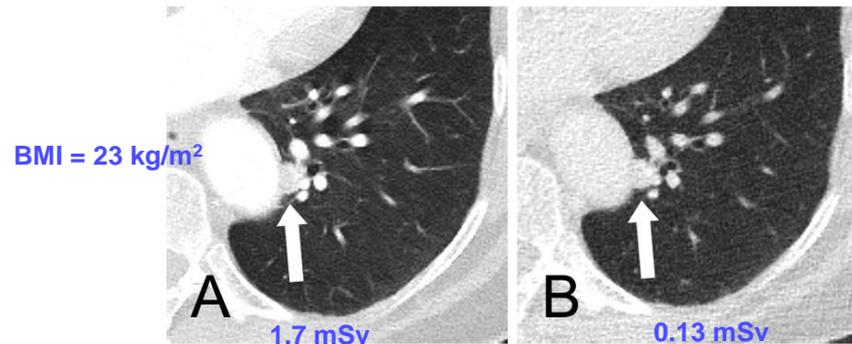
Representative transverse CT sections of the lung in a 73-year-old woman with a body mass index of 23.0 kg/m^2 scanned with standard dose (A) (effective dose 1.68 mSv) and ultralow dose (B) (effective dose 0.13 mSv). A 11 mm solid pulmonary nodule (arrow) in the left lower lobe adjacent to pulmonary vessels and the descending aorta was not detected by computer-aided detection (CAD) software in both protocols (i.e. false negative finding). Note: The lesion was detected in ultralow dose CT by one of the two radiologists.
